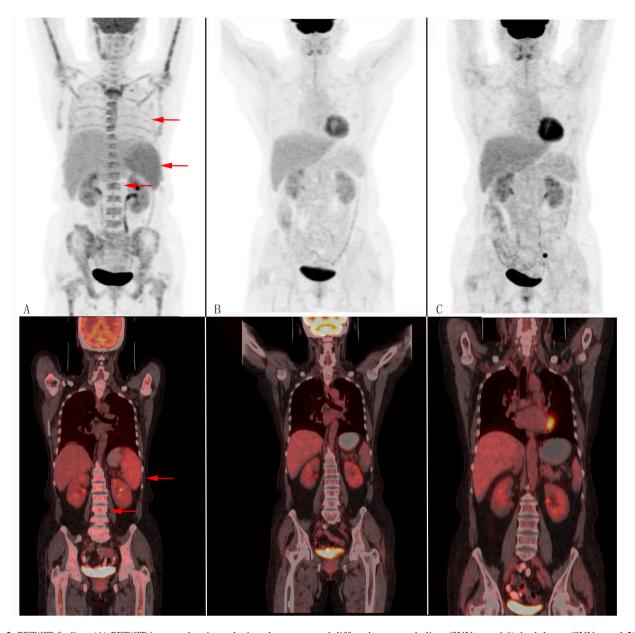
PET/CT finding. (A) PET/CT images showing splenic enlargement and diffuse hypermetabolism (SUVmax=4.6), both lungs (SUVmax=1.5) and bone marrow (SUVmax=1.8-5.9) before treatment (red arrow). (B) The volume and metabolism of the spleen, both lungs and bone marrow are normal after four cycles of treatment. (C) PET/CT images showing metabolism in these organs remaining normal after 8cycles of treatment. PET/CT, positron emission tomography/computed tomography.
